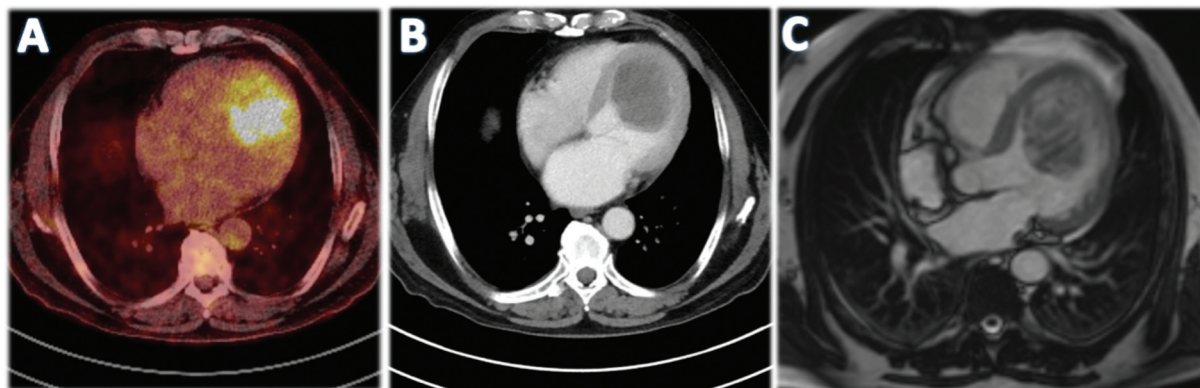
(A) Giant left ventricular mass on fluorodeoxyglucose positron emission tomography. (B) Cardiac computed tomography, axial reconstruction of the sarcoma in the left ventricular apex through the mitral valve. (C) Cardiac magnetic resonance imaging demonstrated irregular borders of the tumor mass.
